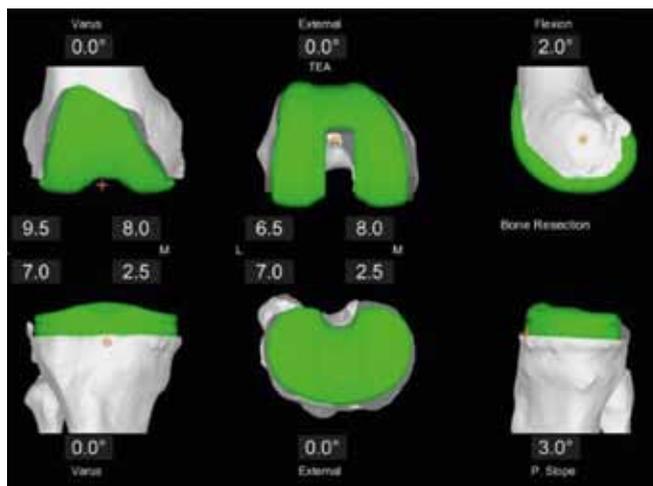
Computer generated images from CT scans of patient's knee to plan surgery pre-operatively.
